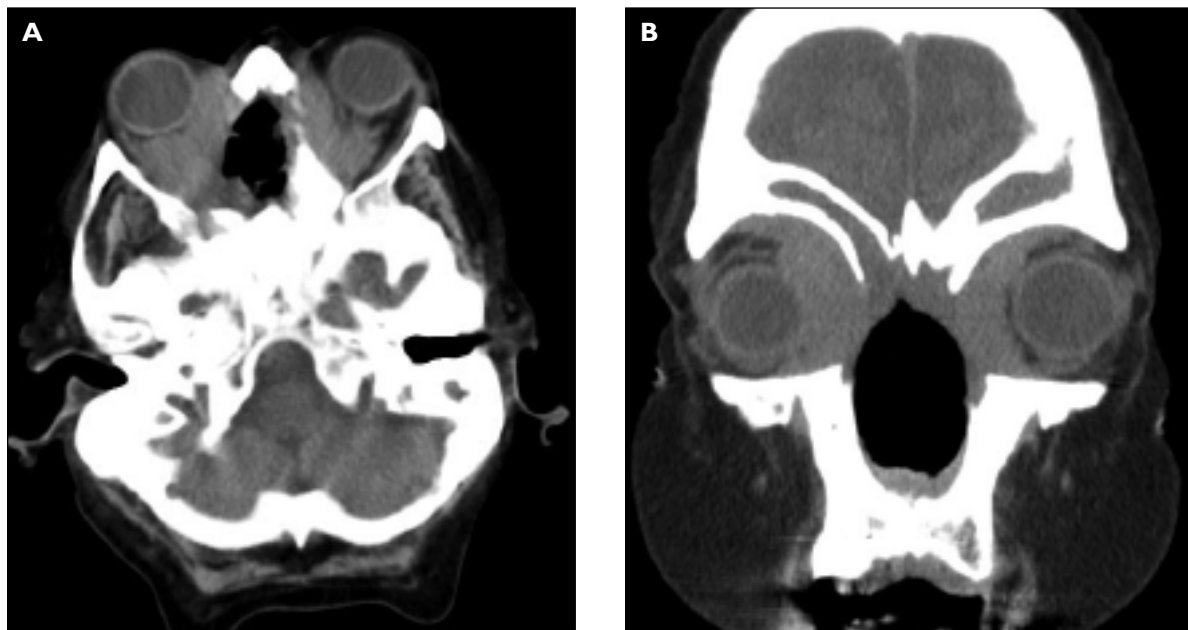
Wegener's granulomatosis patient with retro-orbital mass formation and adjacent paranasal involvement (nasal septal destruction) at computed tomography
